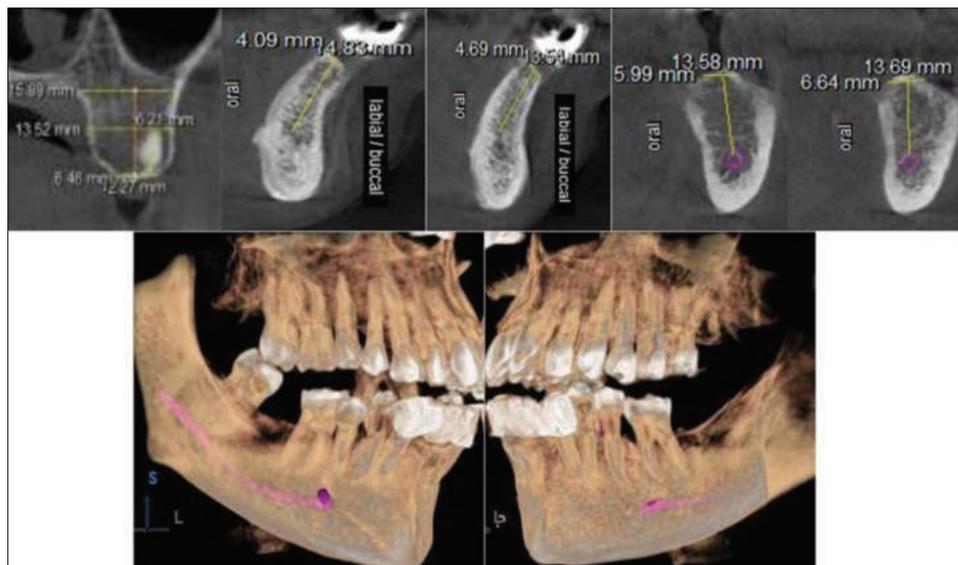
Cone-beam computed tomography imaging providing multiple views for the presurgical evaluation and measurement for placement of implant
